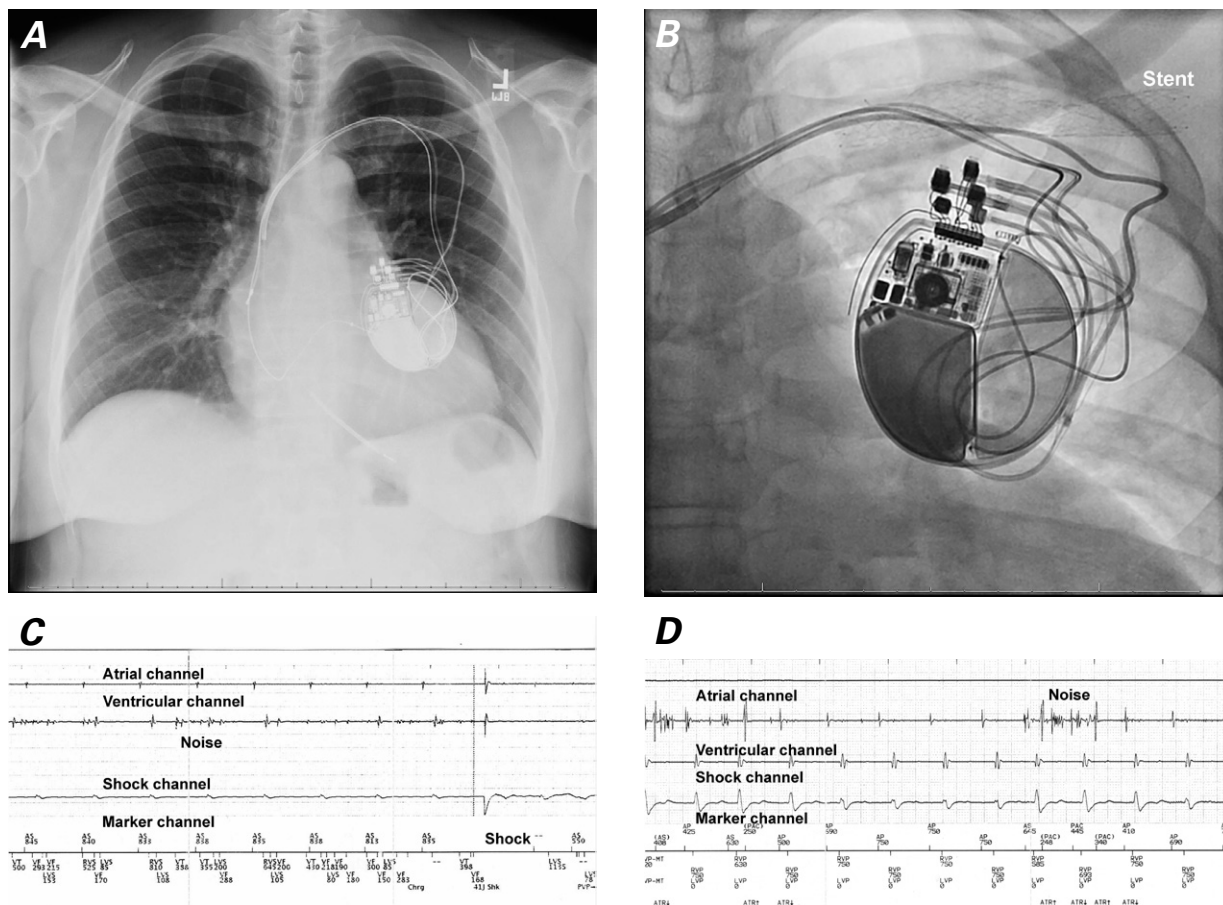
A) Chest radiograph shows the implanted left prepectoral cardiac resynchronization therapy defibrillator. B) Fluoroscopic image shows the stent across the device leads. C) Intracardiac tracings reveal noise in the right ventricular channel, detected as ventricular tachycardia and fibrillation, followed by inappropriate shock. D) Intracardiac tracings reveal noise in the right atrial and right ventricular channels, reproduced by means of isometric exercise.
